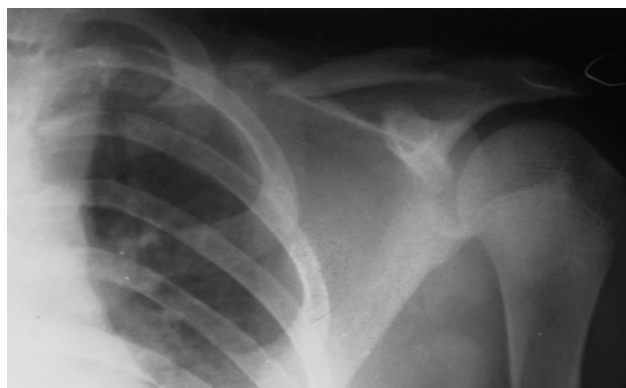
Follow-up radiograph at 22 months postoperatively showing resected medial aspect of clavicle.
